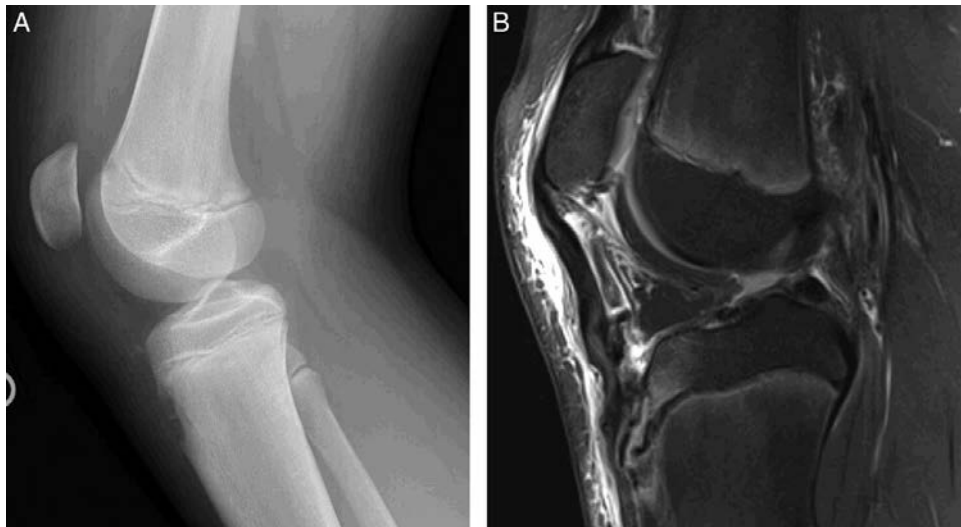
A, Lateral x-ray of a 12-year-old boy who sustained an acute knee injury. No obvious fracture is noted. B, T2 sagittal MRI of the patient in (A) demonstrating a tibial tubercle avulsion and increased intrasubstance signal within the patellar tendon.
